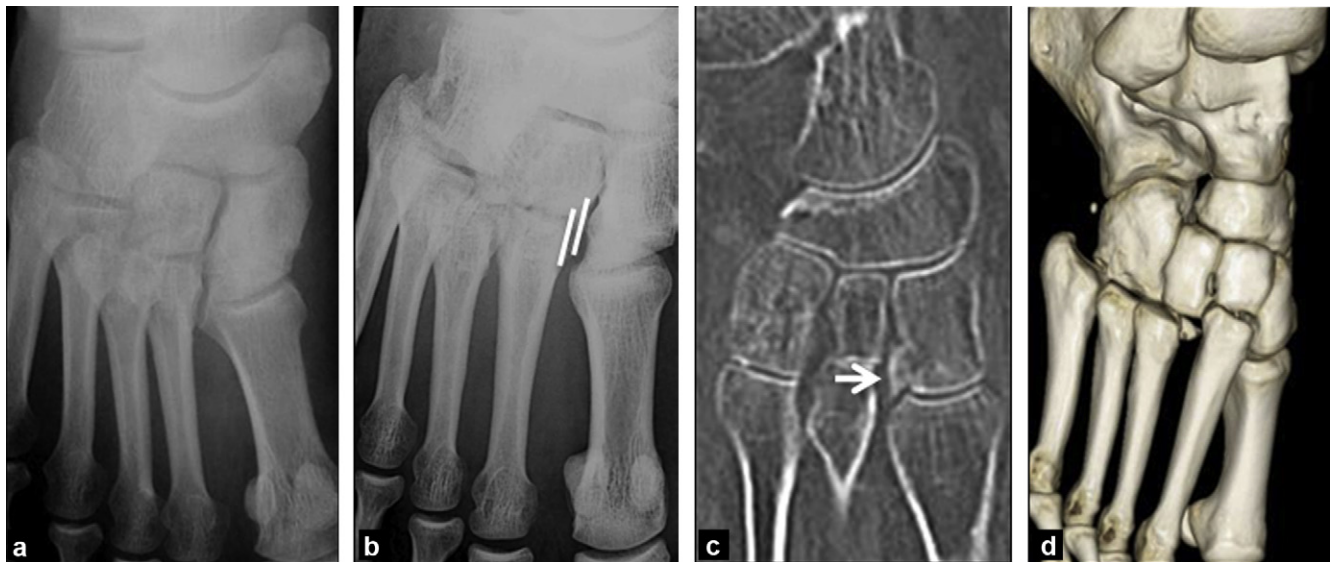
Lisfranc sprain. a: standard X-ray: normal alignment normal of the bone pieces; b: standard X-ray: Lisfranc sprain: loss of normal relationship between the intermediate cuneiform and the base of M2; c: CT (axial) shows the avulsion of the Lisfranc ligament; d: the volume rendering technique (VRT) mode allows for a better study of the anatomical relationships in the major shifts.
